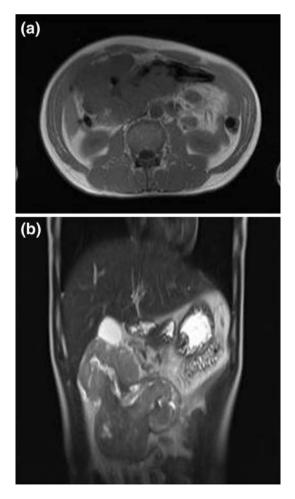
a On magnetic resonance imaging, axial T1-weighted imaging showed a homogeneous lesion isointense to muscle. b Sagittal T2-weighted imaging showed a heterogeneous signal
